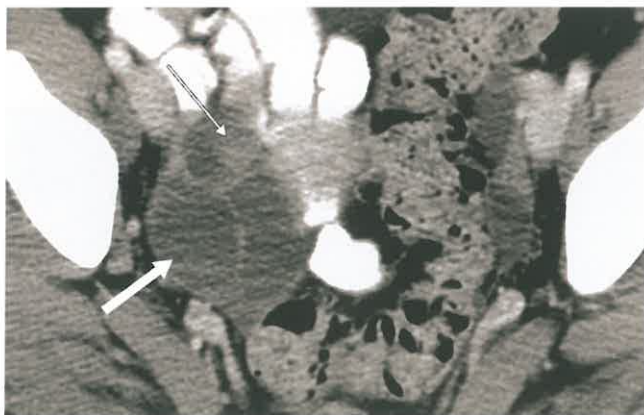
Carcinoma of the Fallopian Tube. Postcontrast CT shows a right sided hydrosalpinx (fat arrow). Close inspection reveals a papillary soft tissue attenuation nodule (skinny arrow) within the lumen of the dilated tube. Surgical resection confirmed adenocarcinoma of the fallopian tube.
